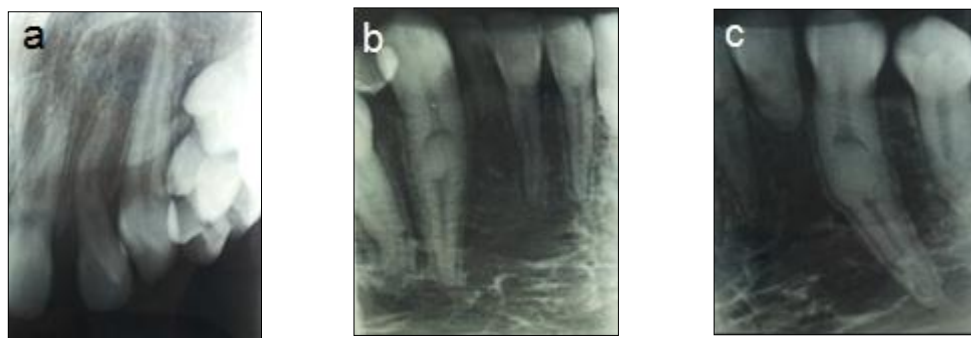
Periapical radiographs (a: upper left region; b: lower right region; c: lower left region)
